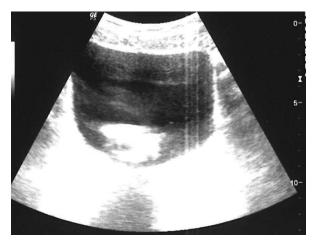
Ultrasonography reporting a stone of 35 mm × 39 mm and emphasizing a strong acoustic shadow.
